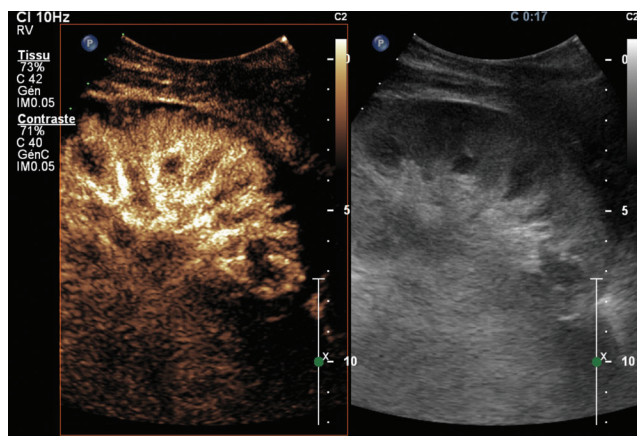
See also color plates. Cortical necrosis. Longitudinal view of a renal allograft in the right iliac fossa in a 7-year-old boy with an allograft dysfunction in the first 24 hours after implantation; suspicion of cortical necrosis. The *right* part of the image shows fundamental imaging at low energy. The *left* part shows contrast-enhanced ultrasound. An avascular rim is clearly visible at the periphery of the kidney, characteristic of cortical necrosis.
